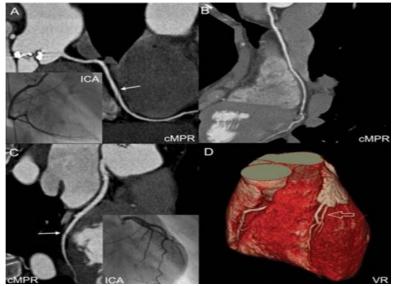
Curved multi-planar reform movements (cMPR) of the RCA (A), LAD (B), & LCX (C) show no stenosis in normal coronary arteries with 64-slice CT coronary angiography & ICA. In the mid-RCA & distal LCX, there are some minor motion artefacts (arrows). By not interfering with artery visualisation, the VR picture (D) defines 3D course of coronary arteries while also presenting venous opacification (open arrow). Right (Inlay in A) & left coronary arteries are normal in the ICA (Inlay in C).
